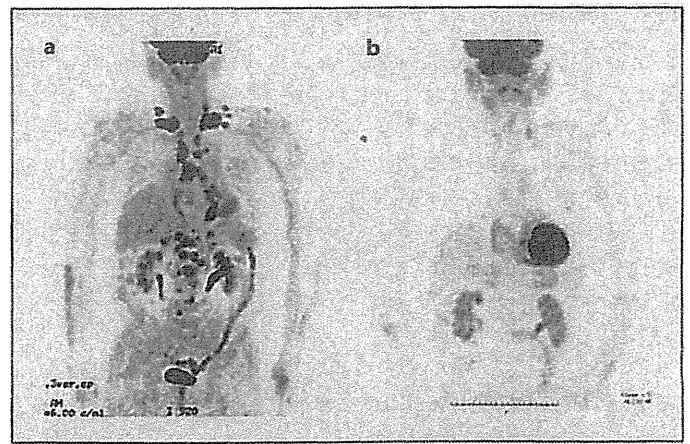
Representative imaging of FDG-PET before (a) and after (b) induction chemotherapy. a Numerous tumors with FDG accumulation are observed in the neck, mediastinum and abdomen before chemotherapy. b FDG accumulation has disappeared after induction chemotherapy.
